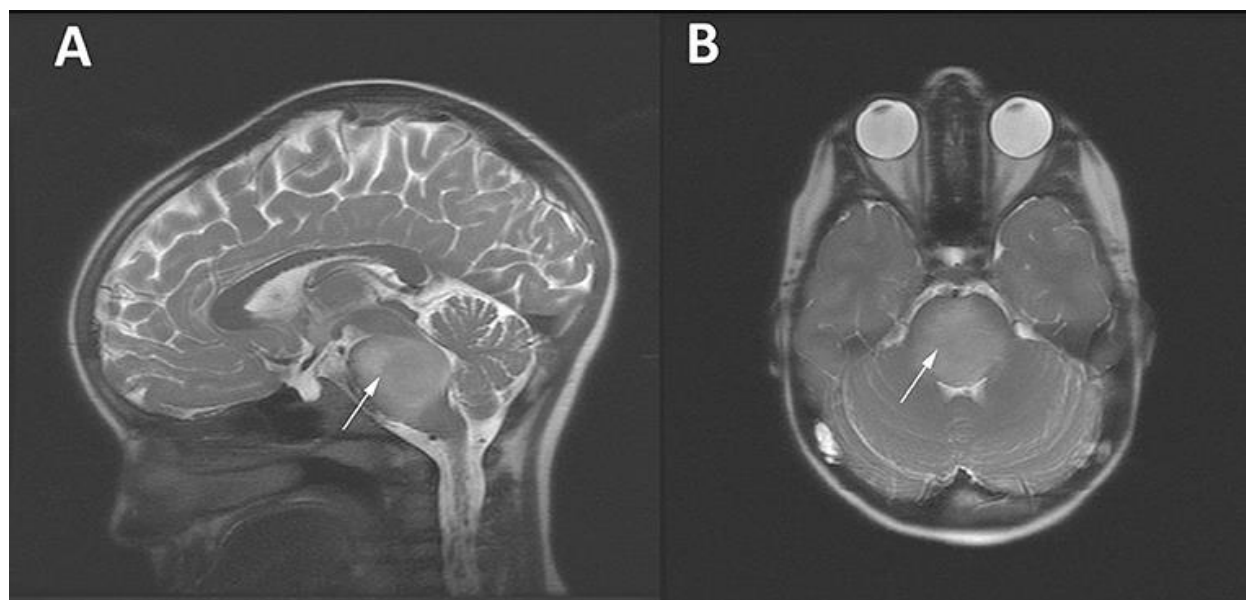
MRI scan of DMG : A sagittal orientation of DMG scan white arrow indicates area of tumor. B Axial orientation of the same DMG tumor white arrow indicates area of tumor. (5)
